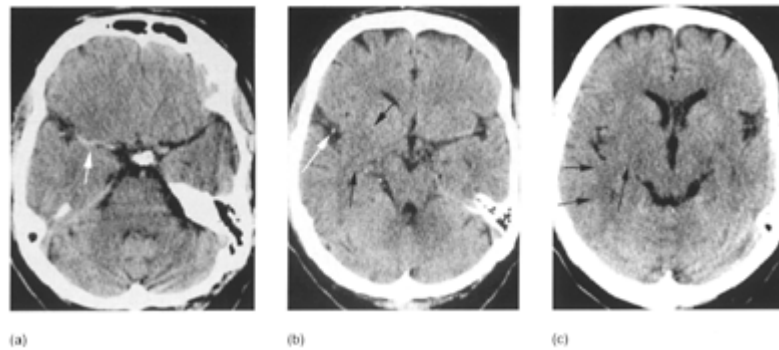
CT of the same patient as in Fig. 5.4 obtained 4 hours after severe clinical deterioration with hemiplegia and sopor.
